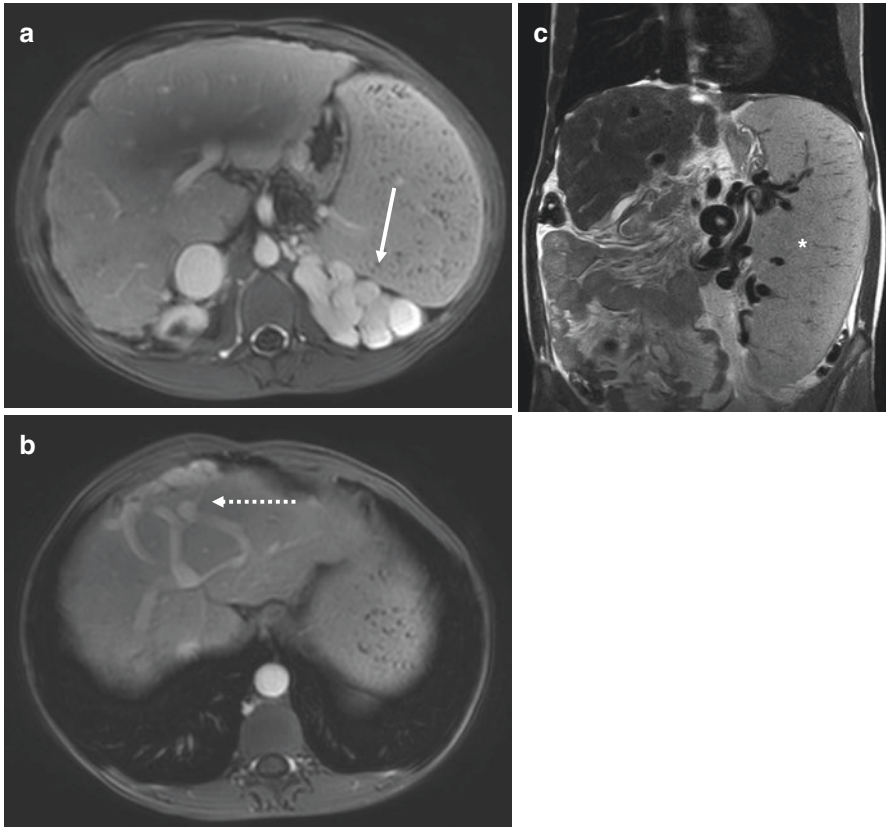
MRI aspect of intra and extrahepatic venous collaterals in a 38-year-old male with myeloproliferative neoplasm. Contrast-enhanced images (portal venous phase a–b) shows enlarged spleno-renal shunts (arrow in a) and multiple intrahepatic venous network (web appearance) with subcapsular course (dashed arrow in b). Note the markedly enlarged spleen on coronal T2-weighted images (star in c)
